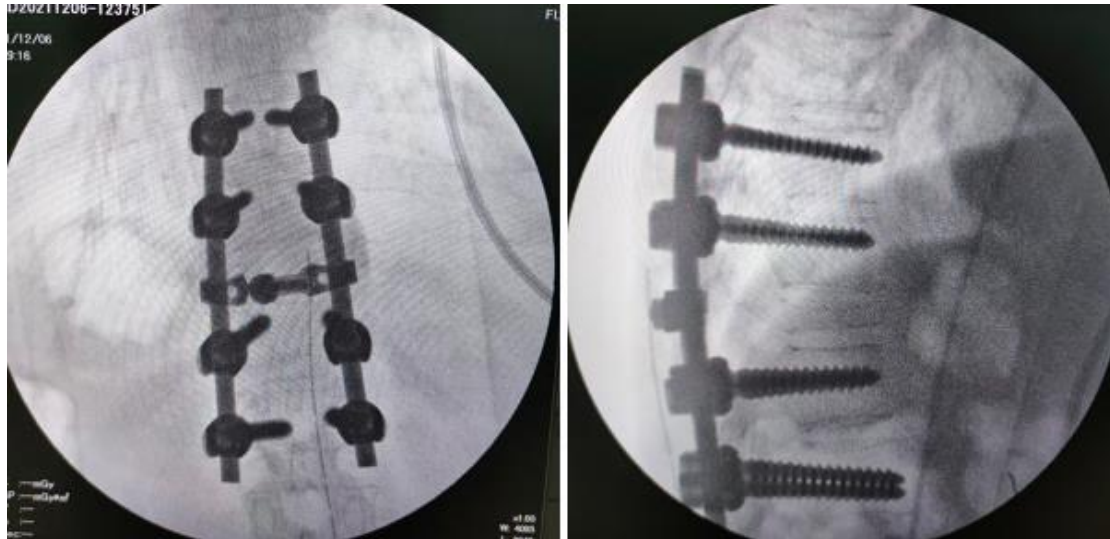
Intraoperatively X-Ray after decompression with stabilization fusion and biopsy.
